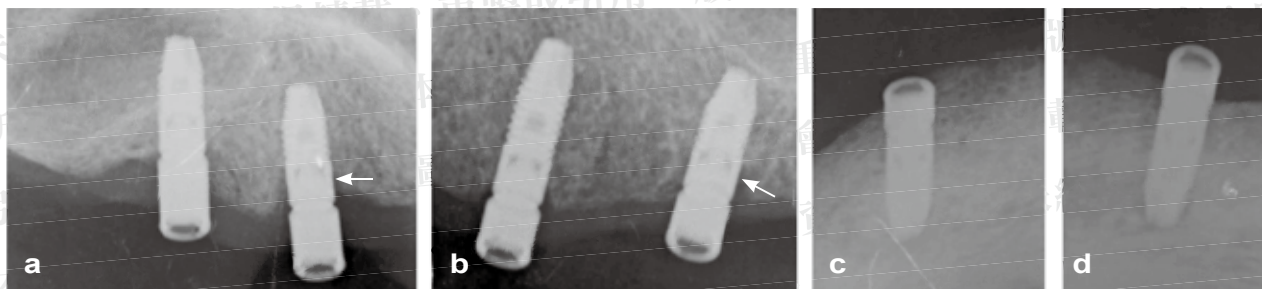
Periapical radiographs taken at the one year follow-up showing that marginal bone loss was more pronounced at the maxillary implants (a & b) (white arrow) compared with the mandibular ones (c & d), which showed a favorable condition with a quite stable bone level.
